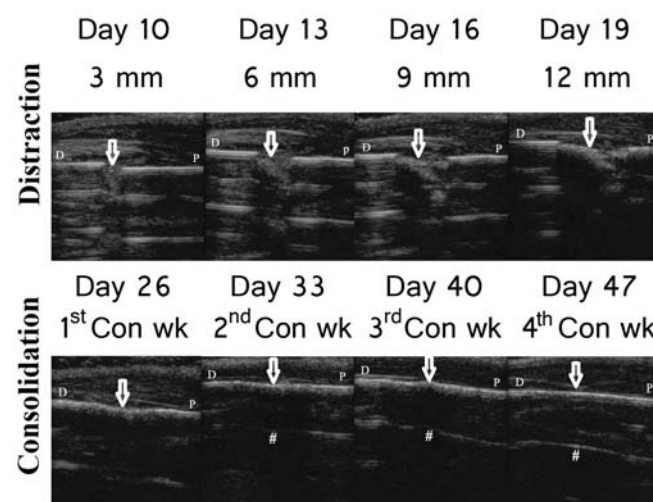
Systemic comparison of representative longitudinal ultrasonographic images during DO treatment; 'D' and 'P' indicates the distal and proximal tibia, respectively. White arrow indicates the location of the bone callus. # indicates the location of the callus reverberation. '3 mm' means the tibia is distracted with a 3 mm gap distance and so on. '1<sup>st</sup> Con wk' means the first week of consolidation and so on.
